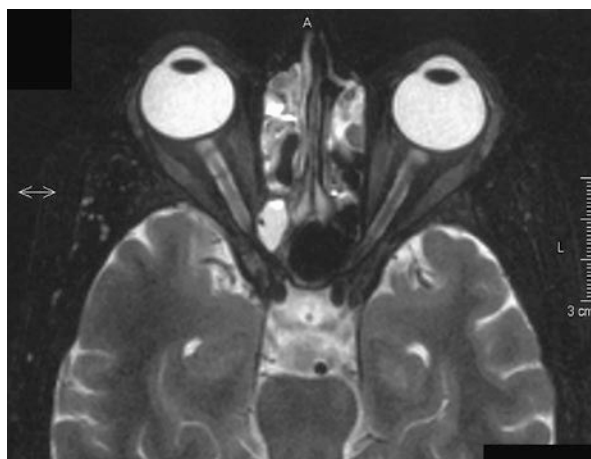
T2 weighted axial MRI showing a high signal mass arising from the posterior ethmoid air cells on the right and extending into the orbital apex causing compression of the right optic nerve
